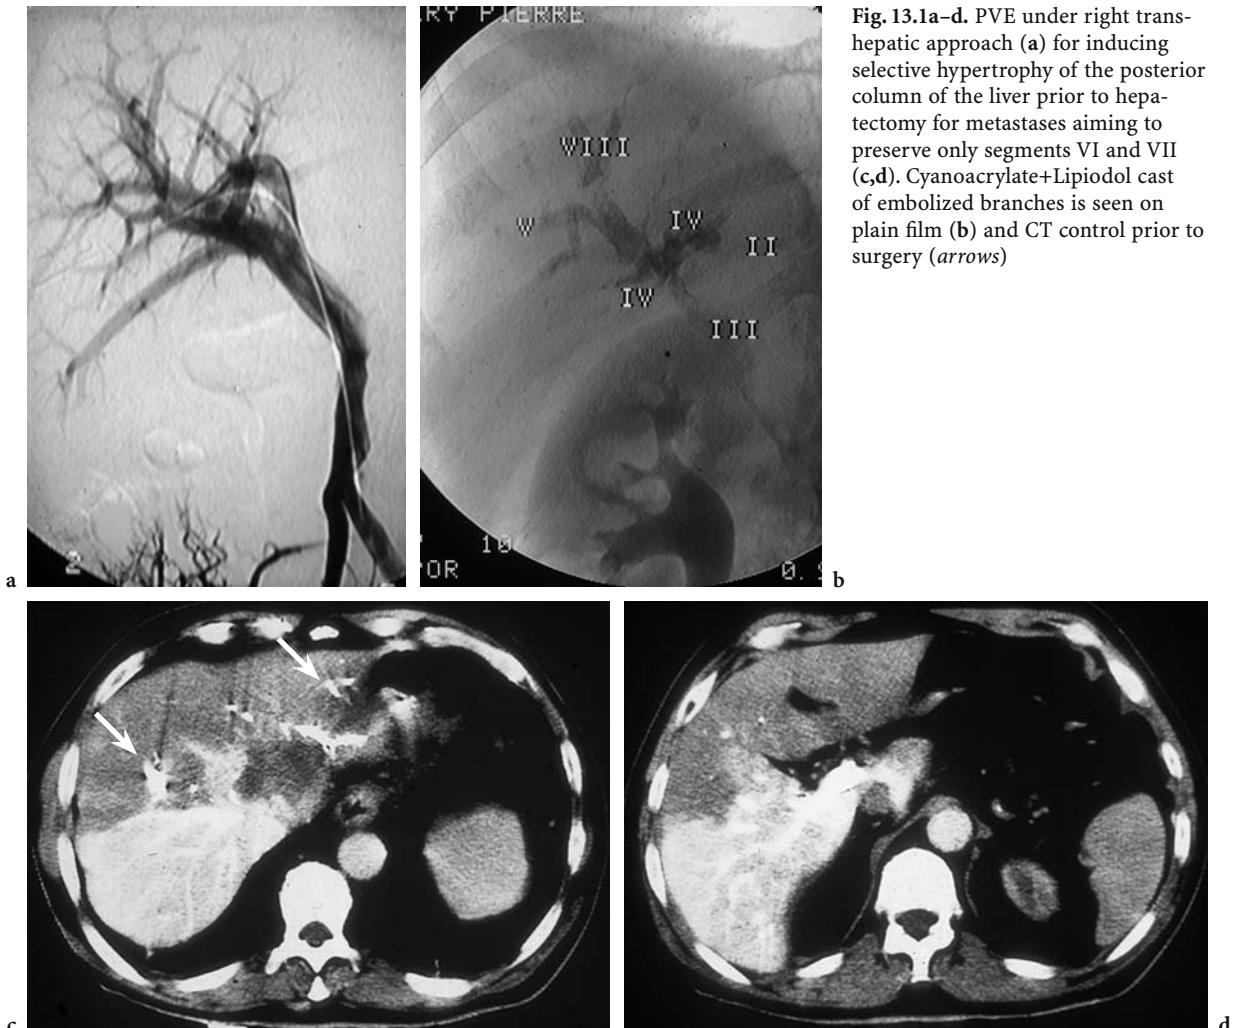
PVE under right transhepatic approach (a) for inducing selective hypertrophy of the posterior column of the liver prior to hepatectomy for metastases aiming to preserve only segments VI and VII (c,d). Cyanoacrylate+Lipiodol cast of embolized branches is seen on plain film (b) and CT control prior to surgery (arrows)
